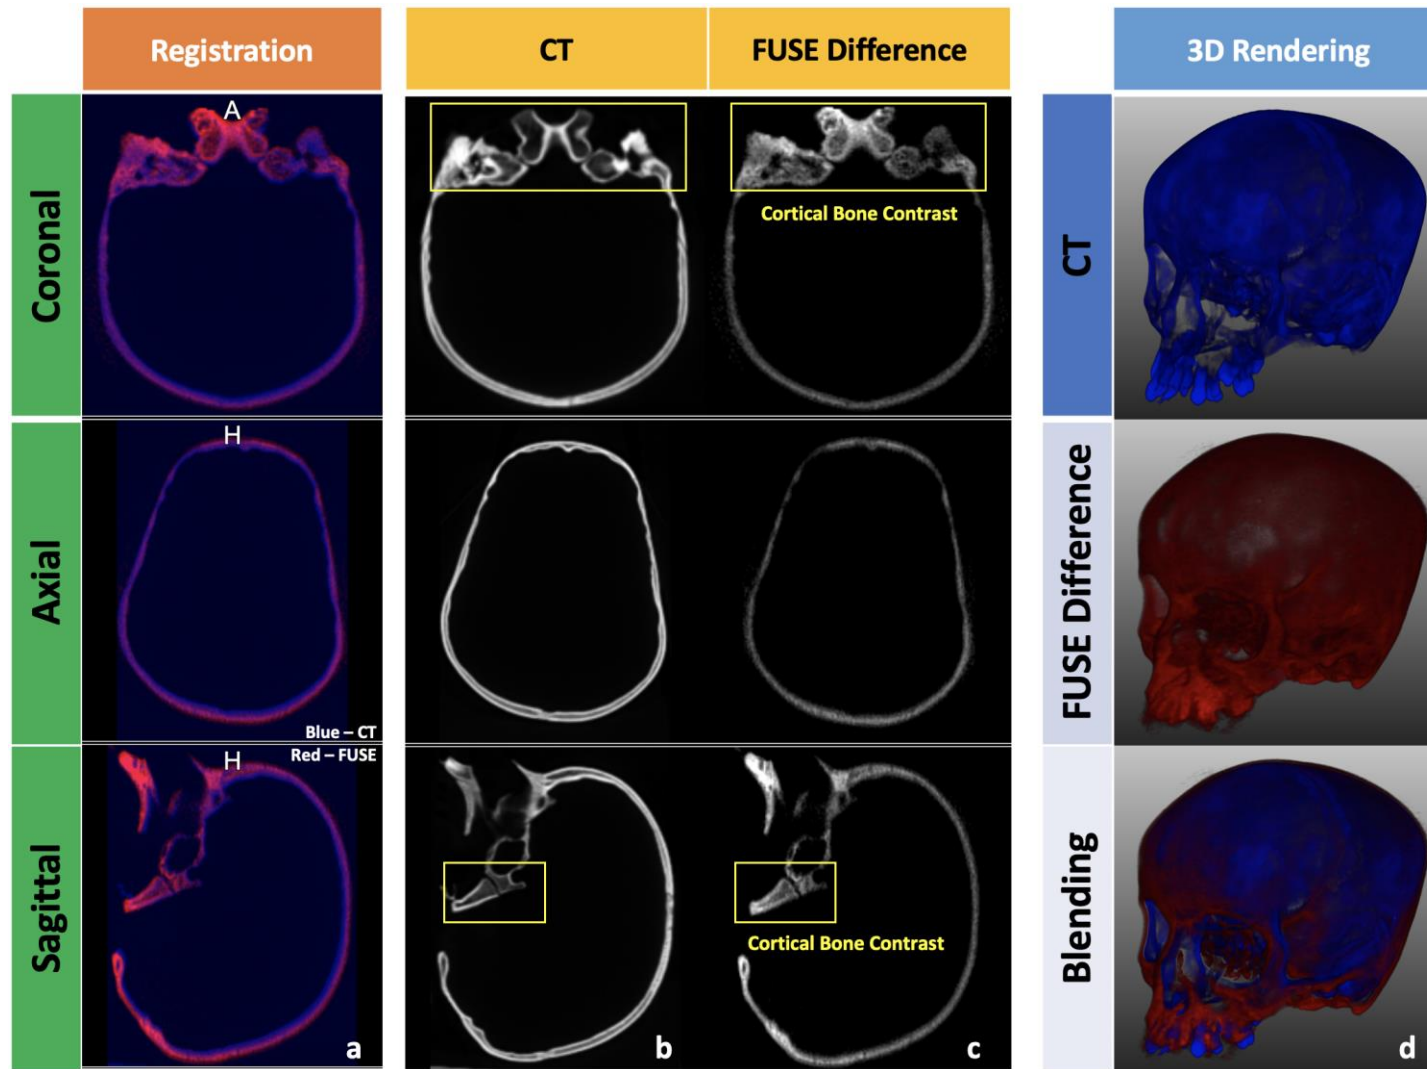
Comparison between CT and FUSE.
